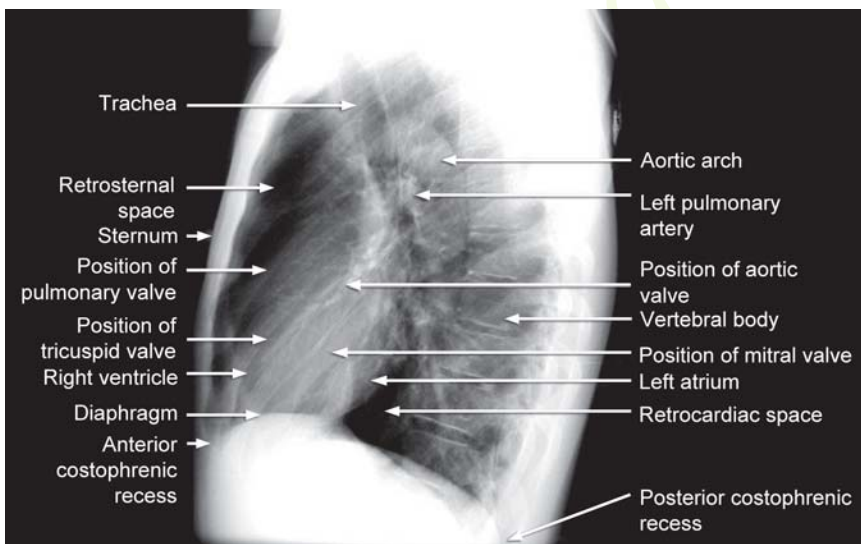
X-ray chest lateral view
